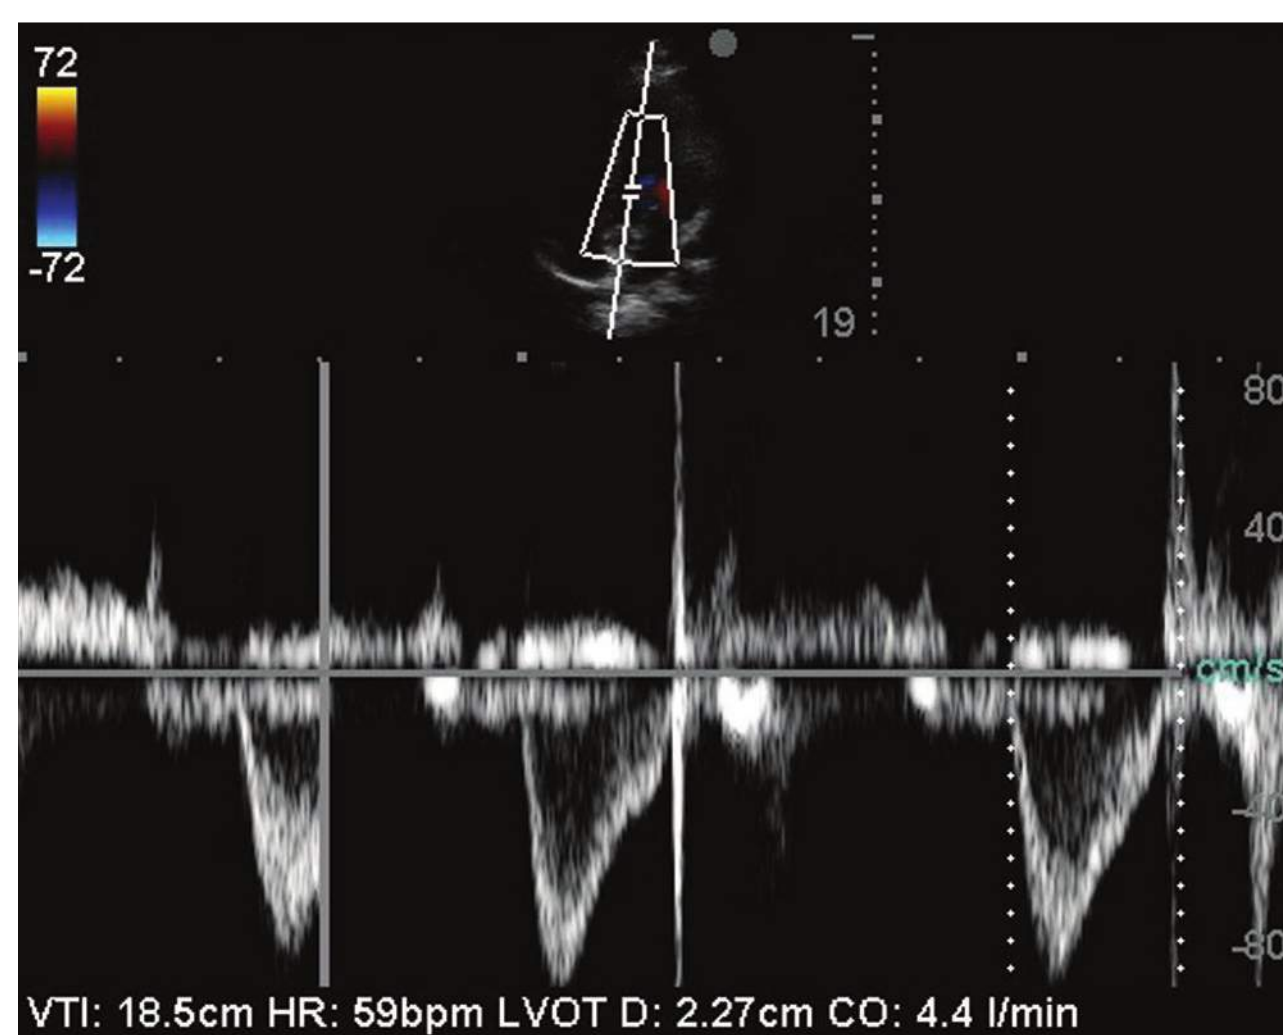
LV outflow tract (LVOT) pulsed wave Doppler. LVOT velocity is plotted under the baseline, blood is moving away from the transducer. The area under the curve is the velocity–time integral (VTI). Using the measured VTI and LVOT diameter, the US system can calculate stroke volume.
